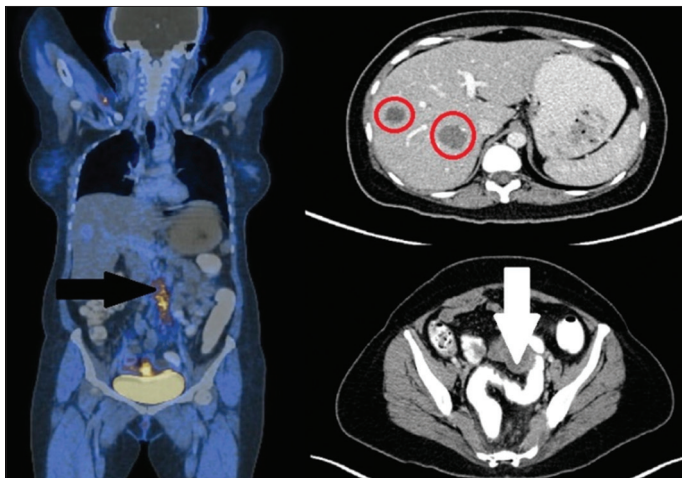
Positron emission tomography-computed tomography whole body scan after neoadjuvant chemotherapy showing thickening of sigmoid colon with left ovarian cyst (white arrow), retroperitoneal nodes (black arrow) and liver lesions (red circle)
